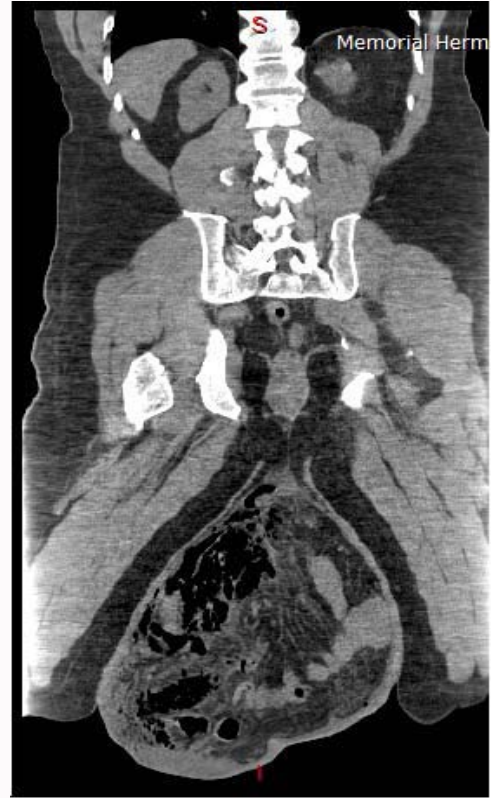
CT scan showing sagittal view of the duodenal herniation.
